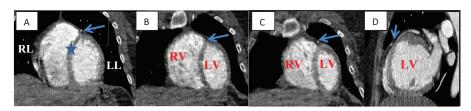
(A–D): Subsequent coronal coronary CT angiography images from A to C (posterior to anterior), the arrows showing left anterior descending artery course. There is intramyocardial course with luminal narrowing of mid LAD on the image B. Normally LAD courses anterior to interventricular septum (star in A) in interventricular groove. The intramyocardial course of mid LAD is also seen on sagittal image (arrows on image D). (LV, left ventricle; RV, right ventricle; LL, left lung; RL, right lung).
